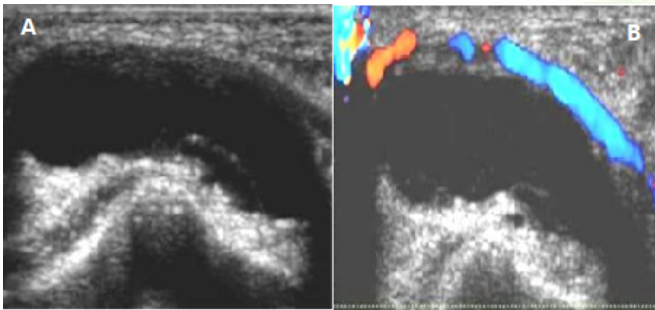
Volar ganglion cyst a) Longitudinal US image and b) with colour doppler showing a well-defined cystic lesion in relation to the distal end of radius adjacent to and deviating the radial artery
